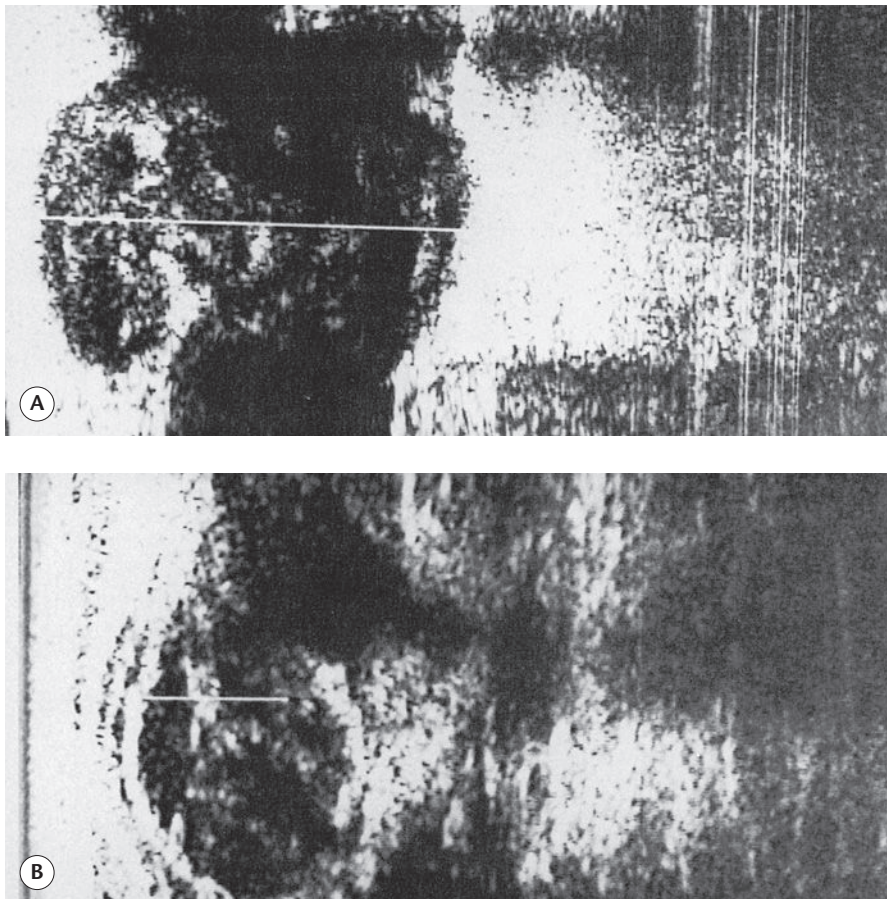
Ultrasound can be used to differentiate thrombosis (A) from sclerosis (B). Horizontal white line indicates the diameter of the vessel. (Courtesy P. Raymond-Martimbeau, MD.)
